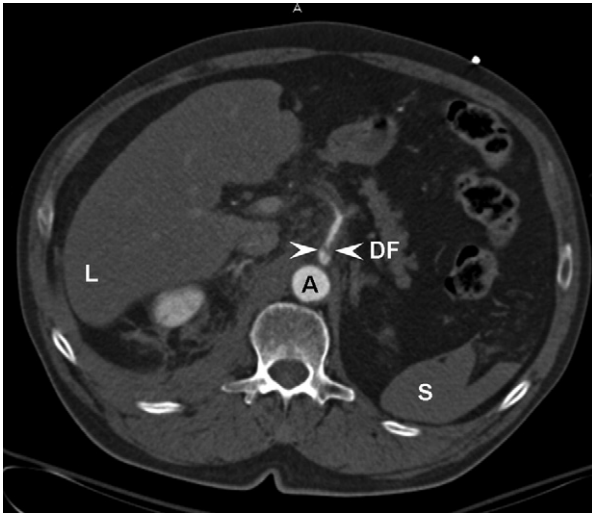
Arterial phase computed tomography scan image of the abdomen performed on day 5 after trauma. For side orientation, the liver (L) and spleen (S) are marked. The image shows the dissection flap (DF) within the celiac artery, originating from the aorta (A). The dissection is characterized by the presence of an intimal flap with concomitant wall hematoma.
